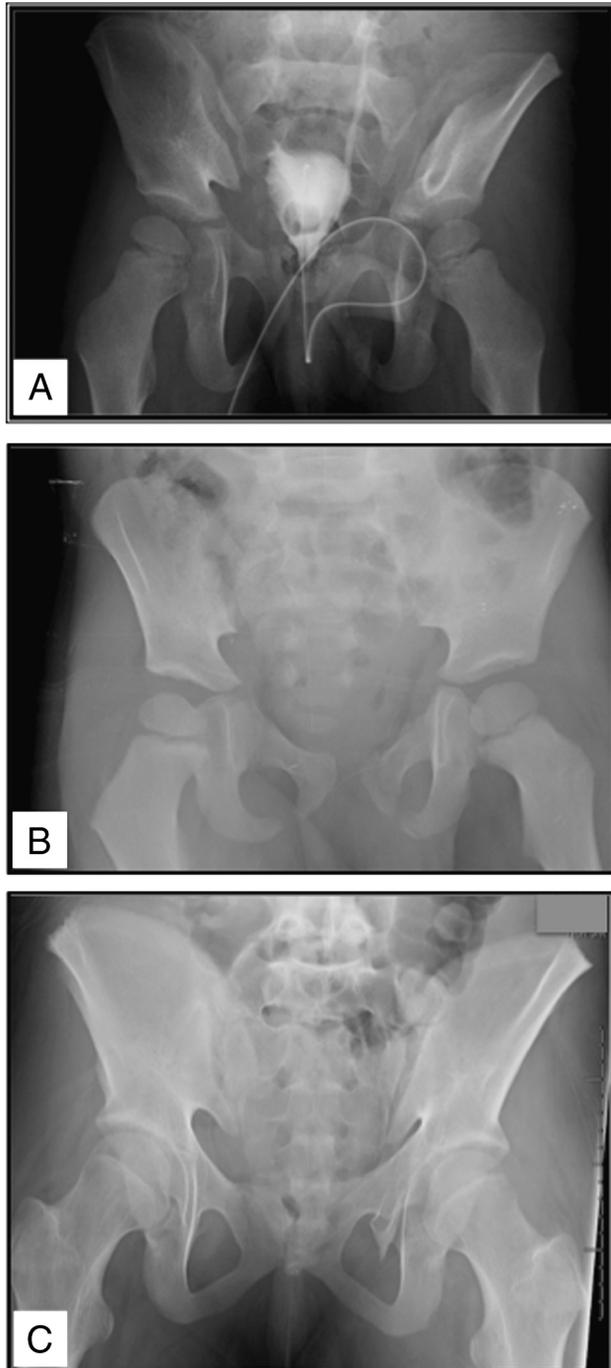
AP pelvic radiographs of three individual pediatric patients evaluated for pelvic fractures. Note the difficulty in evaluating the pubic symphysis in each case. (A) Patient has bladder contrast and bowel gas, a foley guide, and multiple ramus fractures obscuring the borders of the symphysis. (B) Patient has multiple fractures of the rami, and close evaluation of the iliac wing contour and the obturator profiles demonstrates that this image was obtained obliquely such that measurements of the coronal plane structures will be distorted. (C) The film for patient was obtained with a cephalad tilt, thus it is more of an outlet image. Bowel gas and bony overlap of the sacrum and coccyx make measurement of the width of the symphysis very difficult.
